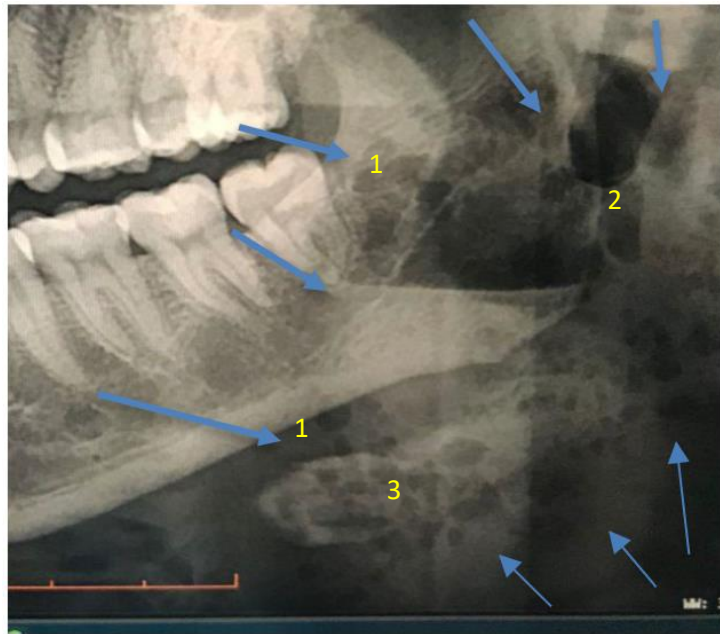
Left panoramic radiographic section
